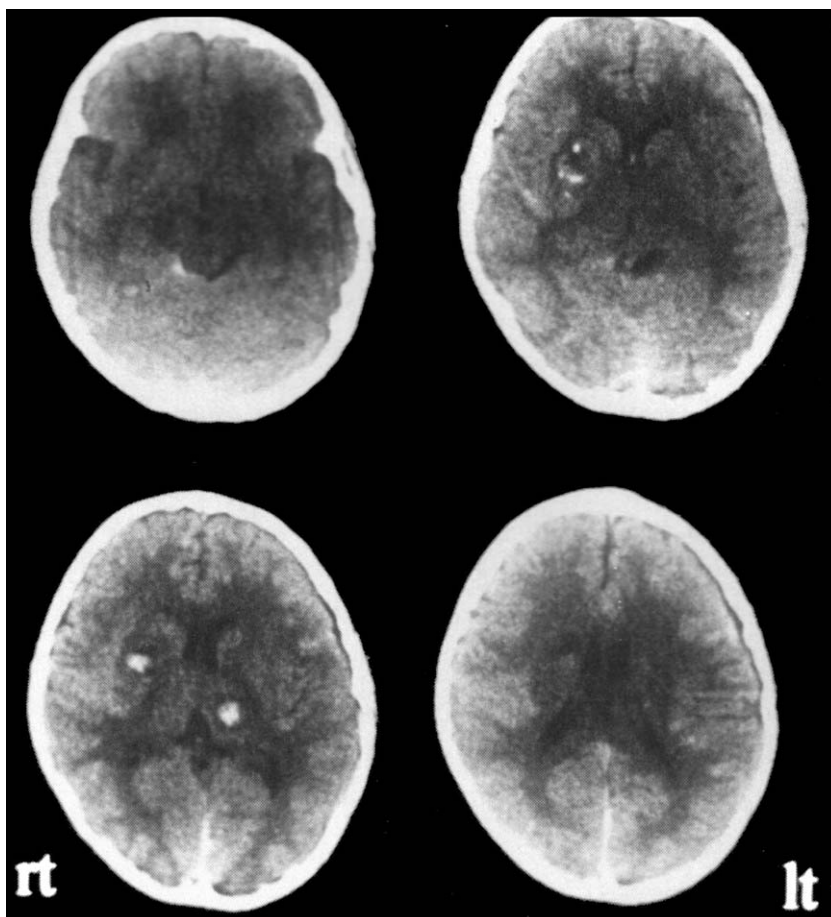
A computed tomographic scan of case 1.
